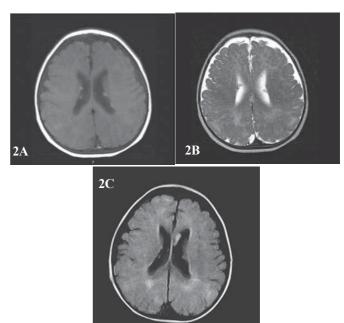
Multiple small subependymal nodules around the lateral ventricles that appear hyperintense to brain parenchymal tissue, as revealed upon a (A) T1-weighted (TE/TR:14/630 ms) image, (B) T2-weighted image (TE/TR:120/5816 ms), and (C) FLAIR (TE/TR:120/6000 ms) image of the patient's brain.
